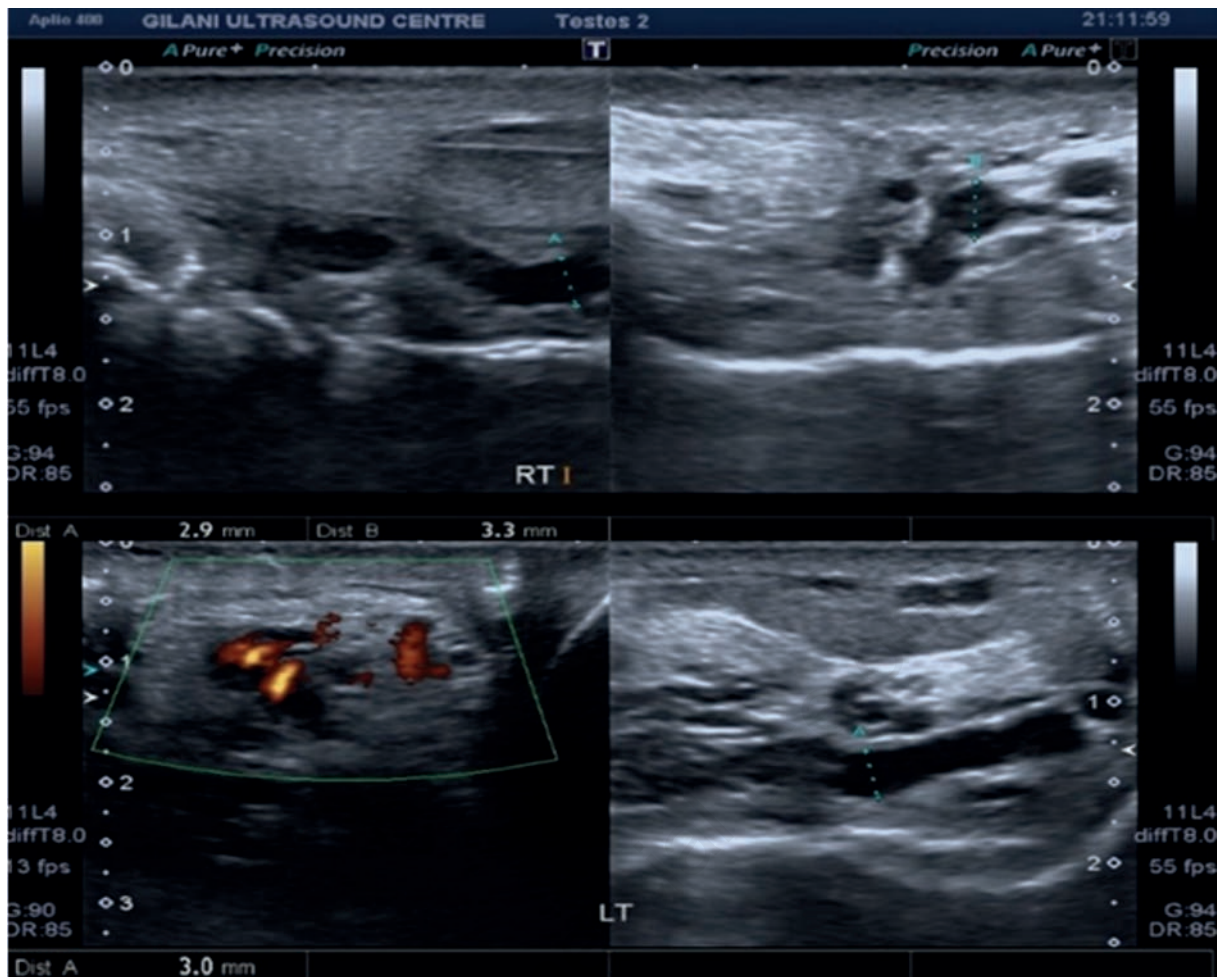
Ultrasound images of a 31-year-old obese patient with varicocele measuring 3.6 mm and 2.9 mm on the right and 3.0 mm on the left.
